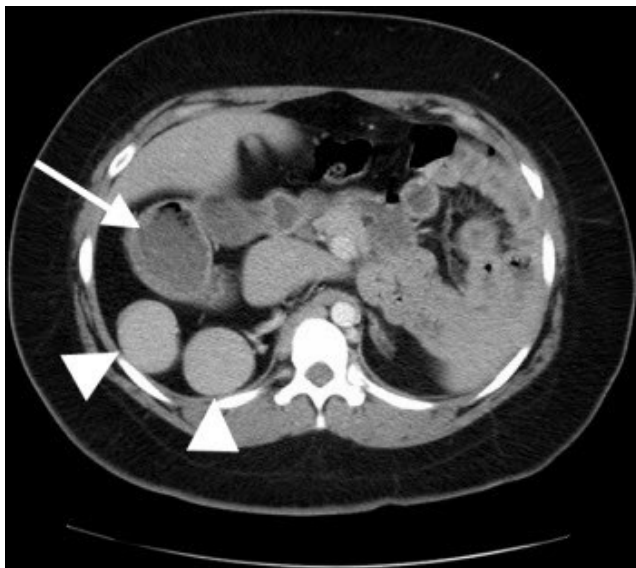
Computed Tomography: A 23 year-old female patient with situs ambiguous with polysplenia. Axial CT with IV contrast shows location of duodenum coming off of the stomach (arrow) located in the right abdomen. Polysplenia is present with splenic tissue (arrowheads) in two distinct locations.
